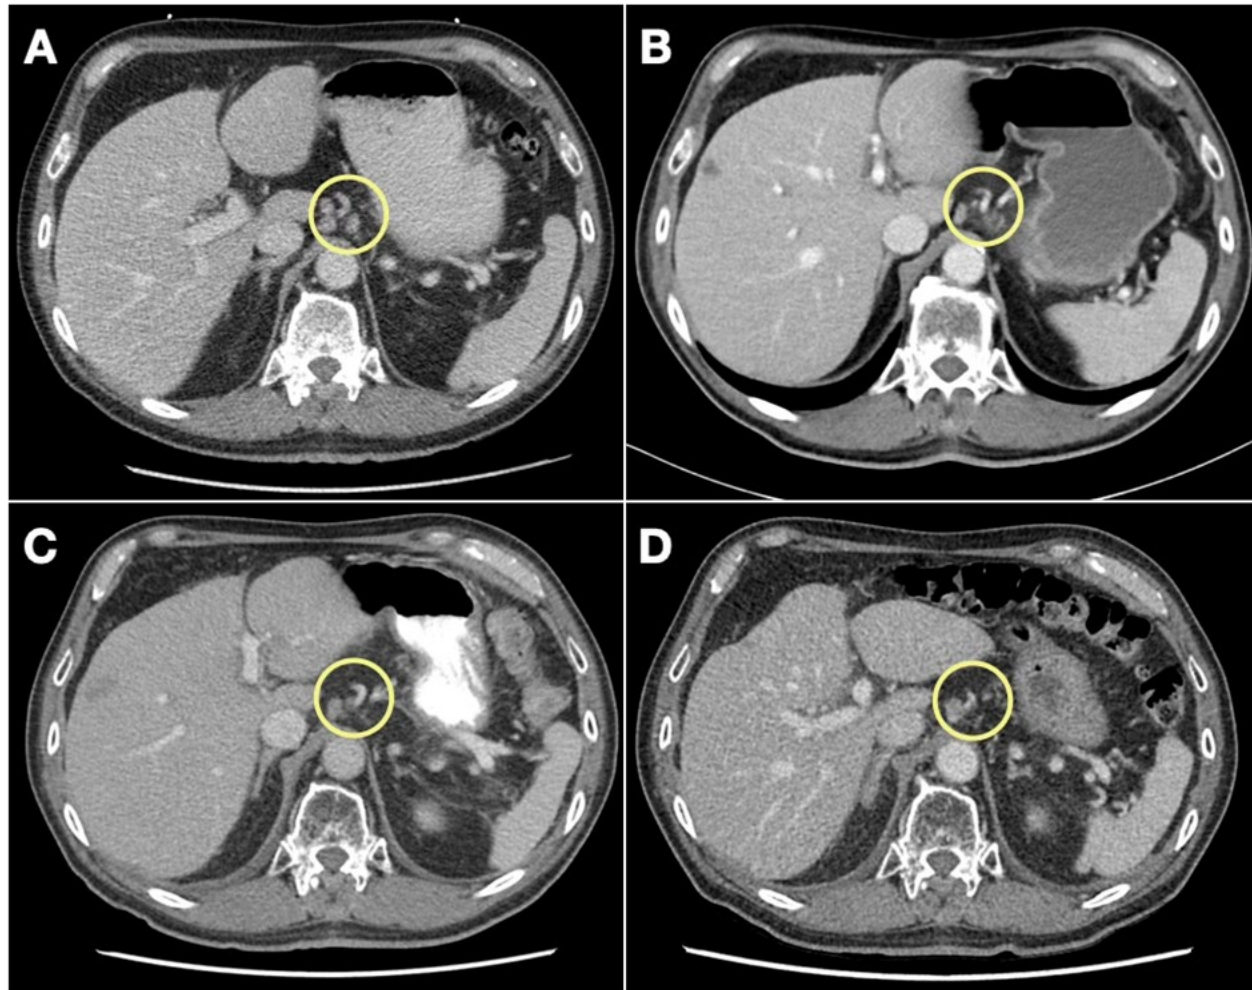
Serial axial computed tomography (CT) images of gastrohepatic lymphadenopathy. (A) Baseline diagnostic imaging in September 2022 demonstrated multiple gastrohepatic lymph nodes. (B) Significant interval reduction in the size of numerous gastrohepatic lymph nodes with almost complete disappearance of the left gastrohepatic node conglomerate in February 2023 after 1 month of chemoimmunotherapy. (C) Mixed response with a small interval increase in the size of a right gastrohepatic lymph node seen in May 2023. (D) Near complete response in the gastrohepatic lymphadenopathy in September 2023 after 8 months of chemoimmunotherapy with the exception of a single slowly growing right gastrohepatic lymph node since February 2023.
